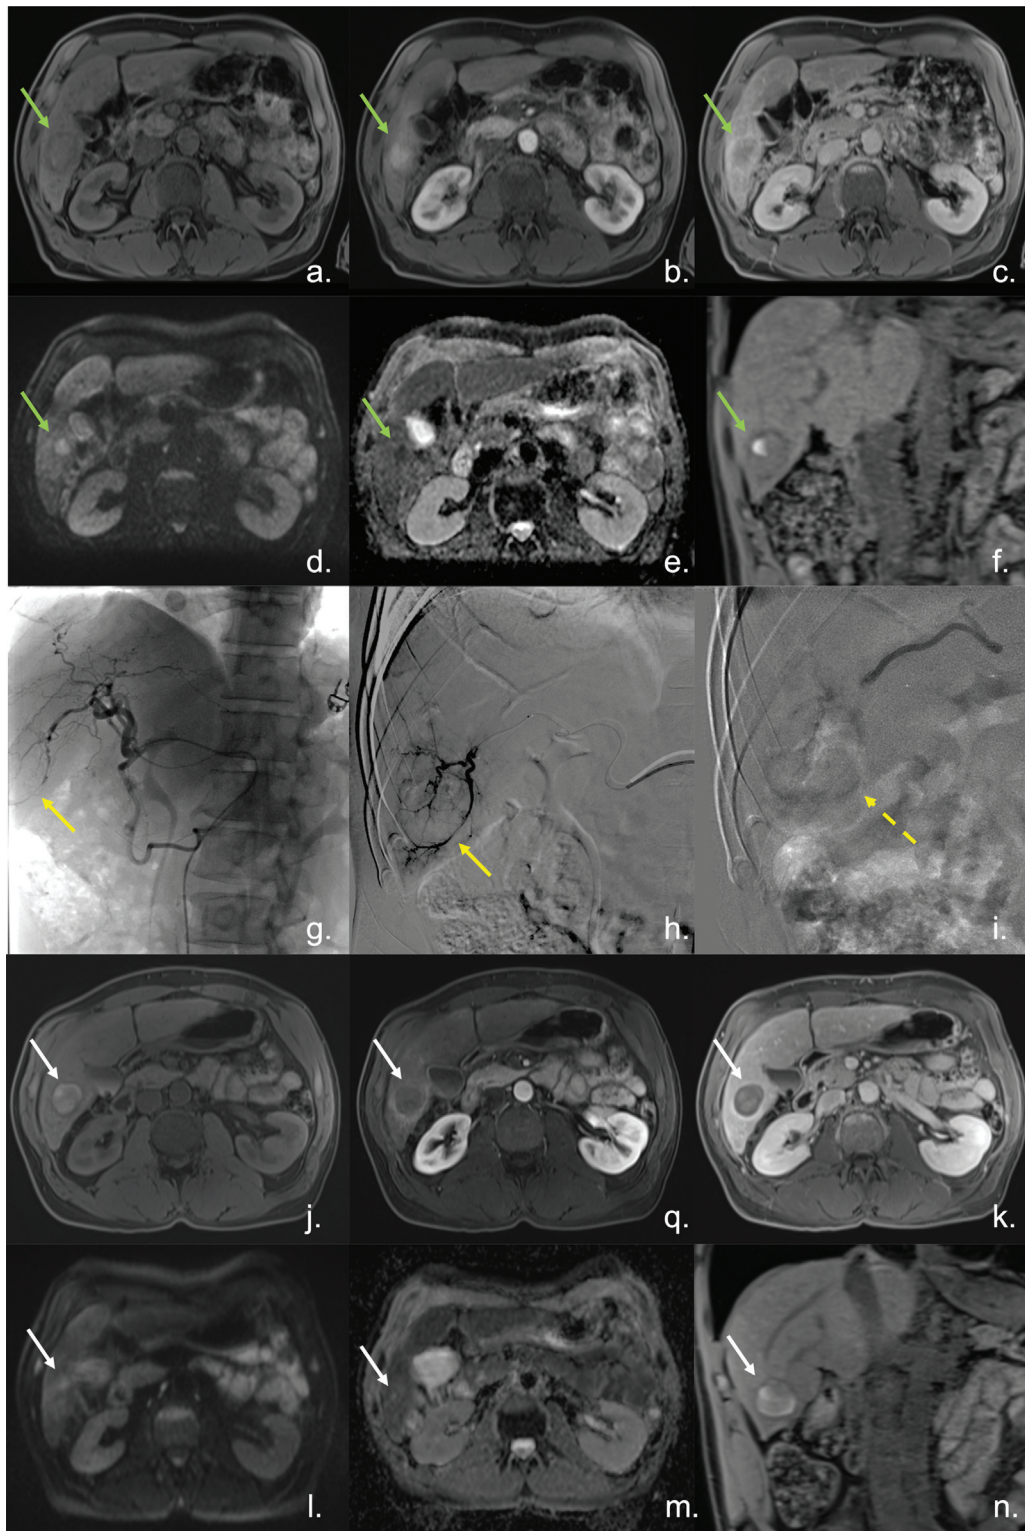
A 55-year-old, hepatitis C virus cirrhotic patient, multifocal hepatocarcinoma, Child–Pugh A–5 points, ECOG 0, BCLC B, in systemic treatment. MRI with lesion in segment VI [green arrow points out a slightly hypointense lesion with hypointense halo on T1 fat sat (a) and small hemorrhagic focus on its interior (f) which enhances early after contrast application (b), presents lavage in the portal phase (c) and restricts diffusion (d = diffusion B 800 and e: ADC)]. He was treated with DEB-TACE, performing supraselective catheterization of the artery that irrigates the lesion of interest using micro guides (g, h), achieving complete embolization with doxorubicin-loaded hepaspheeres (i: postembolization control). In 3 months of control MRI, reduction in solid component of the lesion is observed, with persistence of a minimal halo of peripheral enhancement and a central hemorrhagic transformation component with minimal restriction to diffusion; *mRECIST of partial response* was considered (j: axial fat sat T1, n: coronal fat sat T1, q: early arterial contrast-enhanced T1, k: portal contrast-enhanced T1, l: B800 diffusion, m: ADC).
